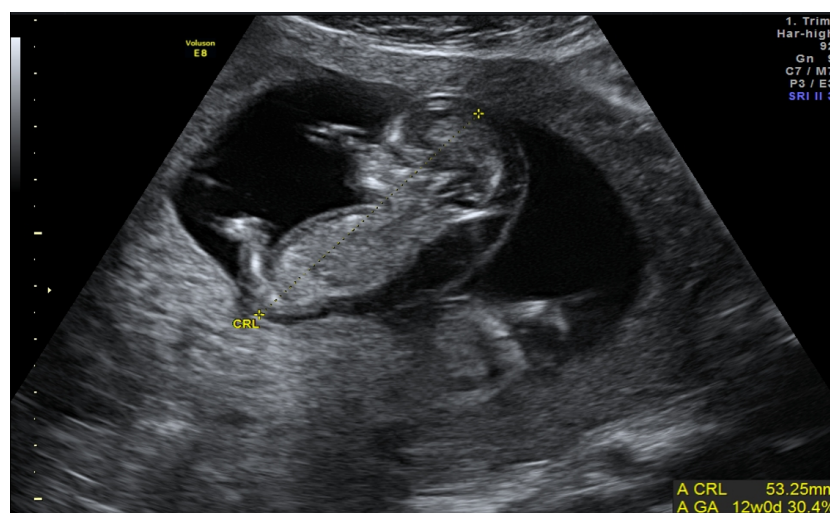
Ultrasound image of the affected twin showing crown-rump length (CRL) measurement highlighting the markedly increased nuchal translucency at 12 weeks.
